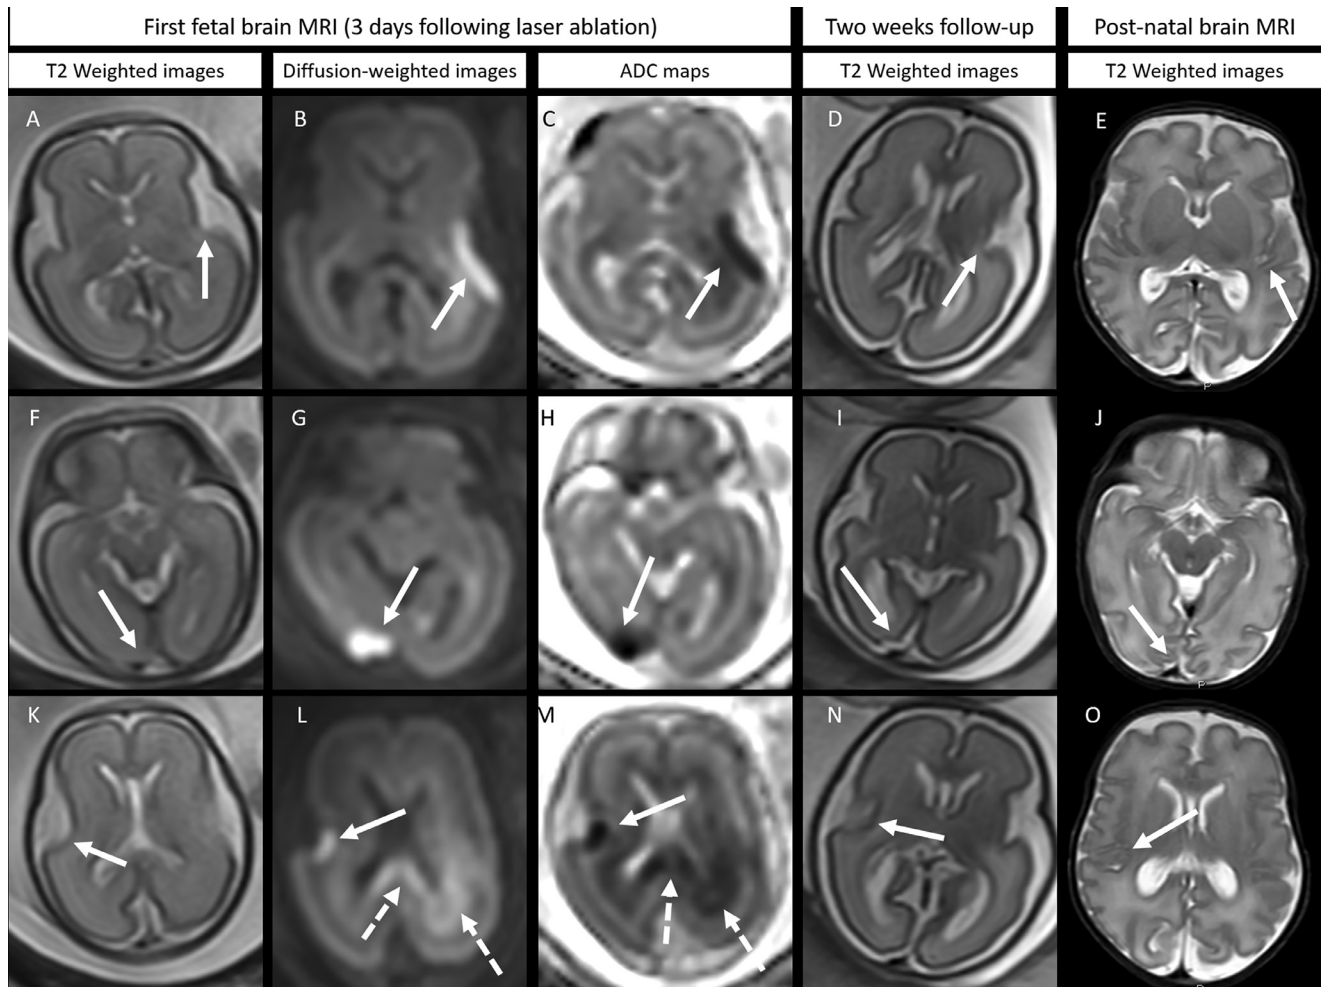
Fetal brain MRI of the survived recipient fetus performed 5 days following the laser procedure, showing multiple areas of mild cortical edema and marked restricted diffusion on left operculum (arrows on A–C), right occipital lobe (arrows on F–H). Images K–M shows area of restricted diffusion suggestive for infarction also in the right operculum (arrows). Notice confluent restricted diffusion also in the left peri-atrial white matter and within the splenium of the corpus callosum, which is also suggestive for ischemic injury. Two weeks follow-up fetal brain MRI shows only subtle areas of cortical irregularities (arrows on D, I) with normal-appearing right operculum. Postnatal brain MRI has confirmed subtle findings, as seen on the two weeks follow-up study (arrows on E, J, and O).
